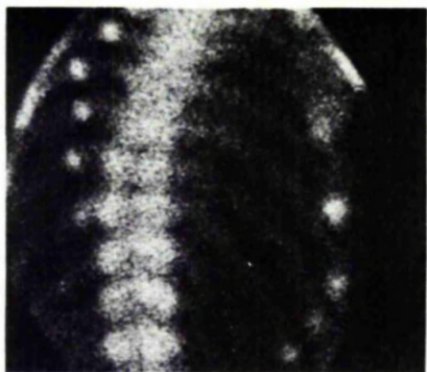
Dorsolumbar spine. Multiple hot spots in ribs. Radiographs confirmed pseudofractures at these sites.
